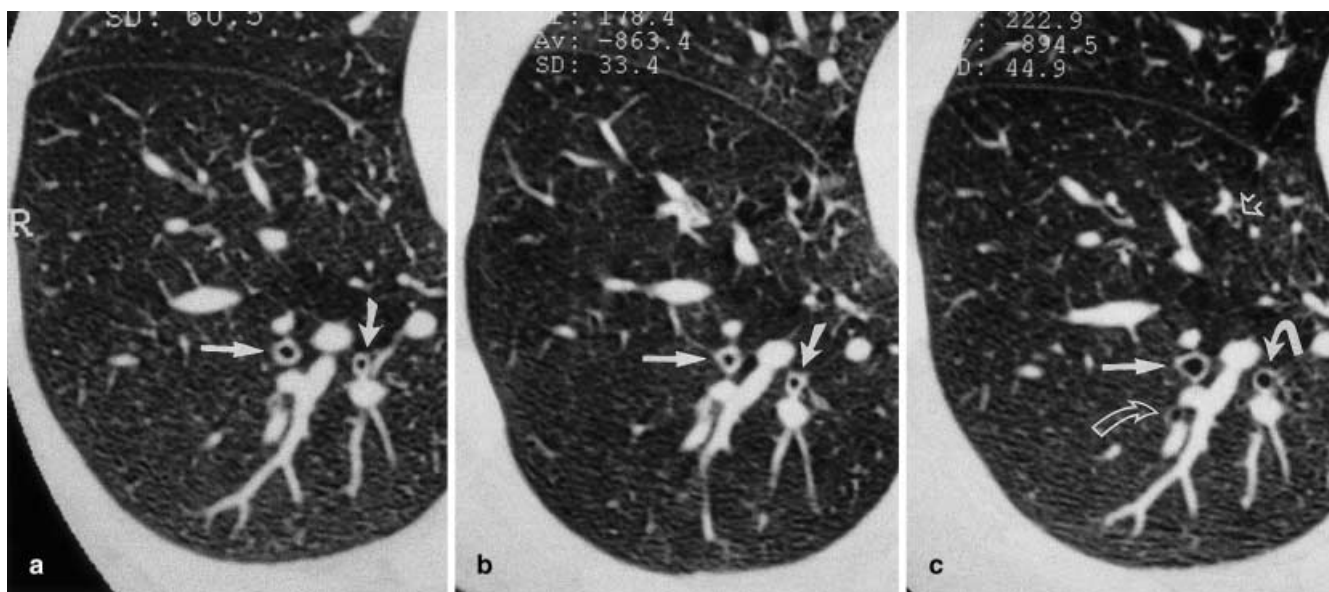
Airway hyperresponsiveness in mild intermittent asthma. Thin-section CT scans targeted on the right lower lobe at 65% of total lung capacity controlled by spirometrical triggering, a at baseline, b after methacholine inhalation, and c 10 mm after salbutamol inhalation. The cross sections of two thick-walled subsegmental bronchi of the posterobasal segment of the right lower lobe (*white arrows*) present with a certain degree of constriction after methacholine (b). After salbutamol (c), the bronchial lumens dilated and appear larger than before challenge. Other small bronchial lumens (*open arrows*) not previously visible have dilated sufficiently to be depicted after salbutamol
